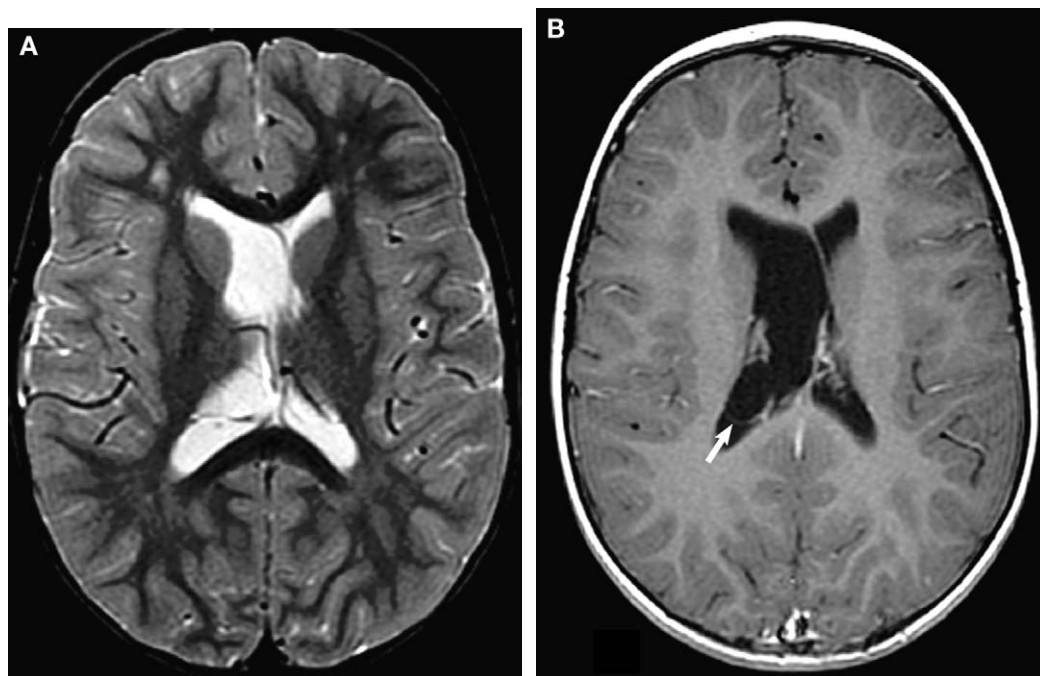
Ependymal cyst. (A) Axial T2-weighted image demonstrates asymmetric lateral ventricles with deviation of the septum pellucidum. (B) Axial T1-weighted postcontrast image confirms the presence of an intraventricular cyst with cerebrospinal fluid intensity with visualization of the posterior margin of the cyst wall (arrow). Imaging findings are consistent with an ependymal or arachnoid cyst.
